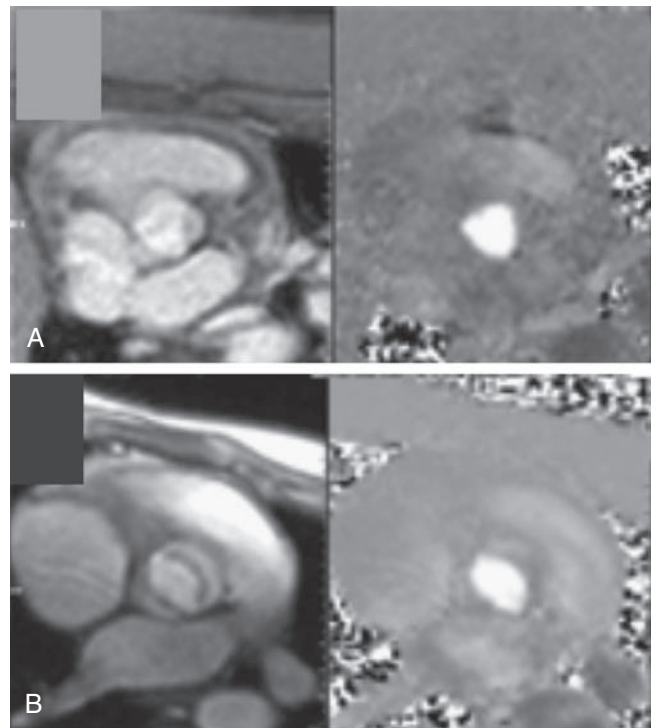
■ Aortic valve structure shown by cardiac MRI. Anatomy is shown on the left and blood flow on the right side of each panel. Cardiac MRI is able to visualize the aortic valve more consistently than transthoracic cardiac echo. This figure shows normal tricuspid (A) and bicuspid (B) aortic valves.
